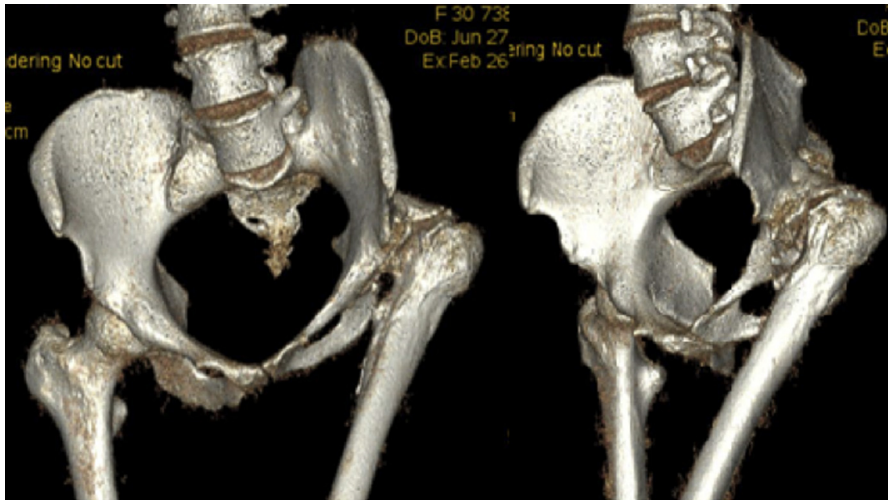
Three-dimensional reconstructions of the pelvic CT scan demonstrate left SI joint autofusion and abnormal external rotation and extension of the left ilium relative to the contralateral hemipelvis.
